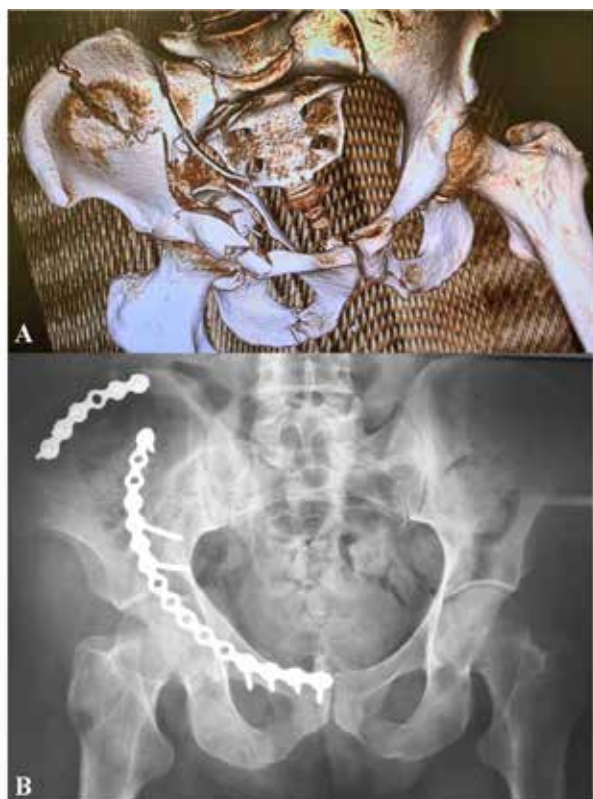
(A,B). Complex acetabular fracture. A- 3D CT after the injury; B- X- ray after the surgery.
